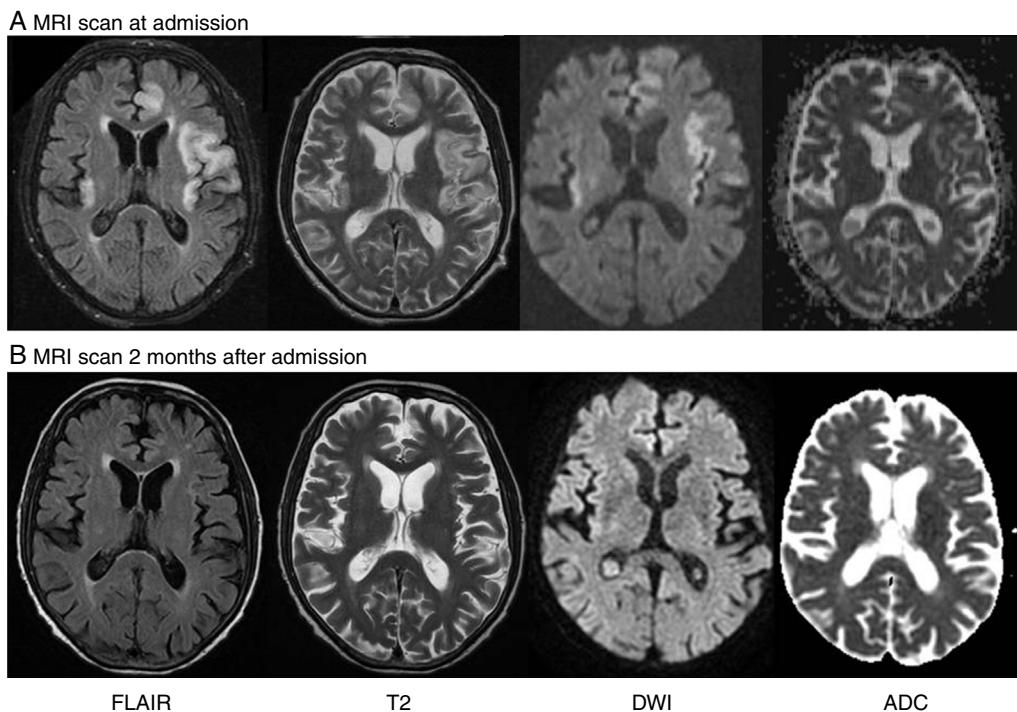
(A) Brain MRI revealing cortical and subcortical hyperintensity in both insular areas, the left temporal lobe, and the parasagittal frontal lobe on T2-weighted and FLAIR sequences. DWI showed cortical signal alterations in all these areas, with no abnormal diffusion restriction in the ADC map. (B) A second MRI scan performed 2 months later revealed that lesions had disappeared.
